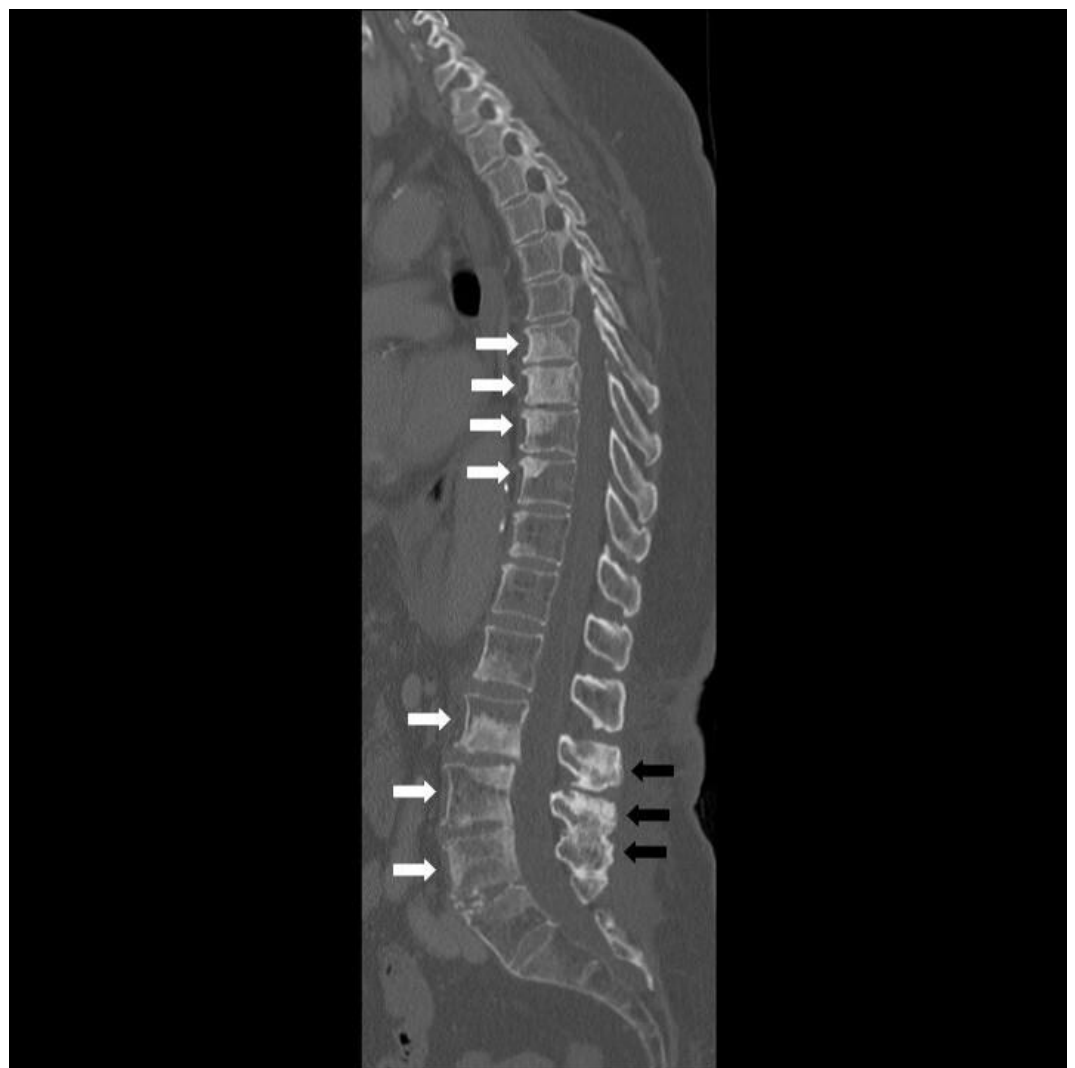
Computed tomography shows sclerosis in vertebral bodies, mainly T8 to T11 and L3 to L5 (white arrows), and sclerosis and hypertrophy of spinous processes of lower lumbar bodies (black arrows).
